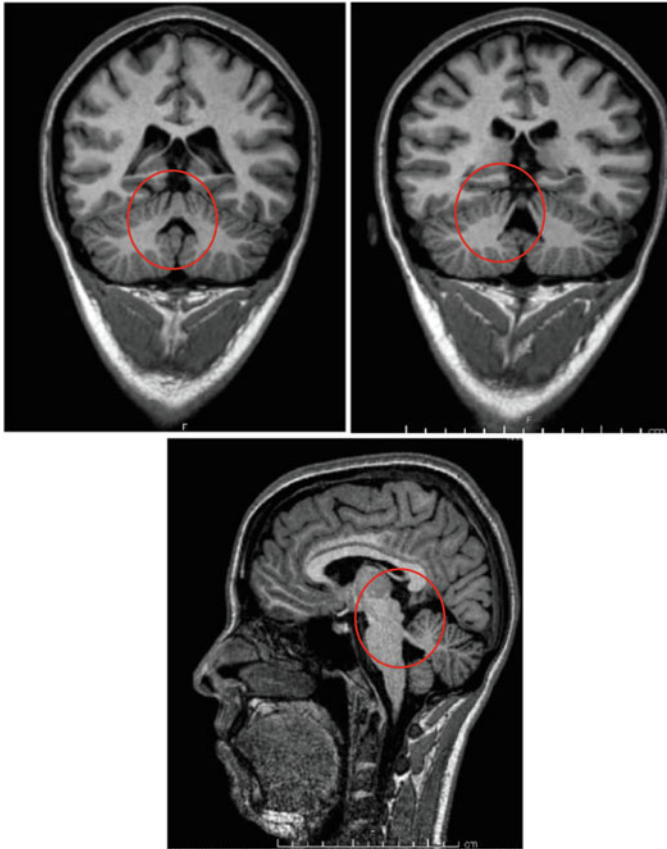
T1-weighted sagittal and coronal images showing mild hypoplasia of the cerebellar vermis
